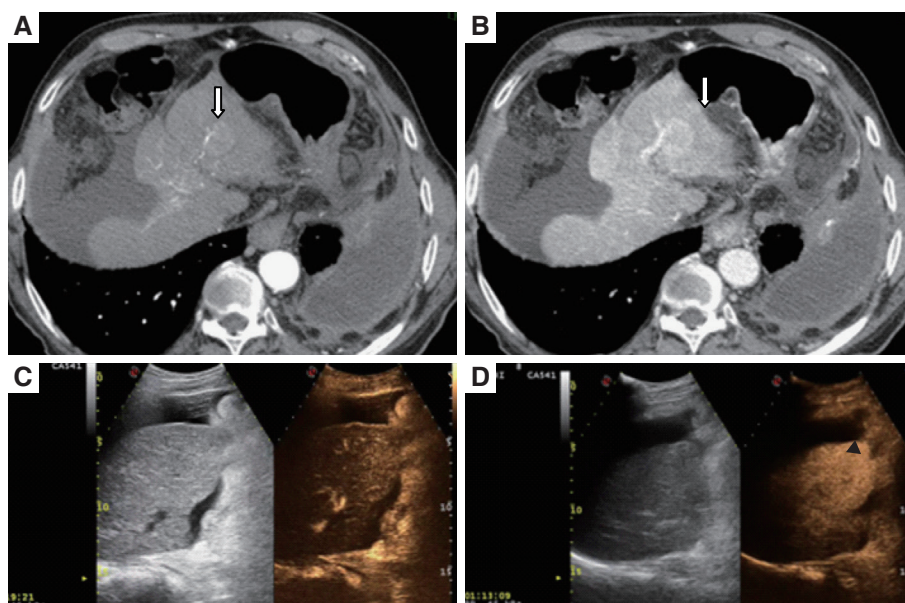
Arterial phase (A, C) and portal phase (B, D) seen in MSCT and CEUS in the same patient with hepatocarcinoma. MSCT (A, B) allows a good documentation of the nodular lesion (arrows) slightly hypervascular in the arterial phase with wash-out in the portal phase. In CEUS the lesion, not detected in B mode, is isovascular in the arterial phase (C); in the portal phase (D) is slightly hypovascular (black arrow head). MSCT: multislice computed tomography; CEUS: contrast enhanced ultrasound
